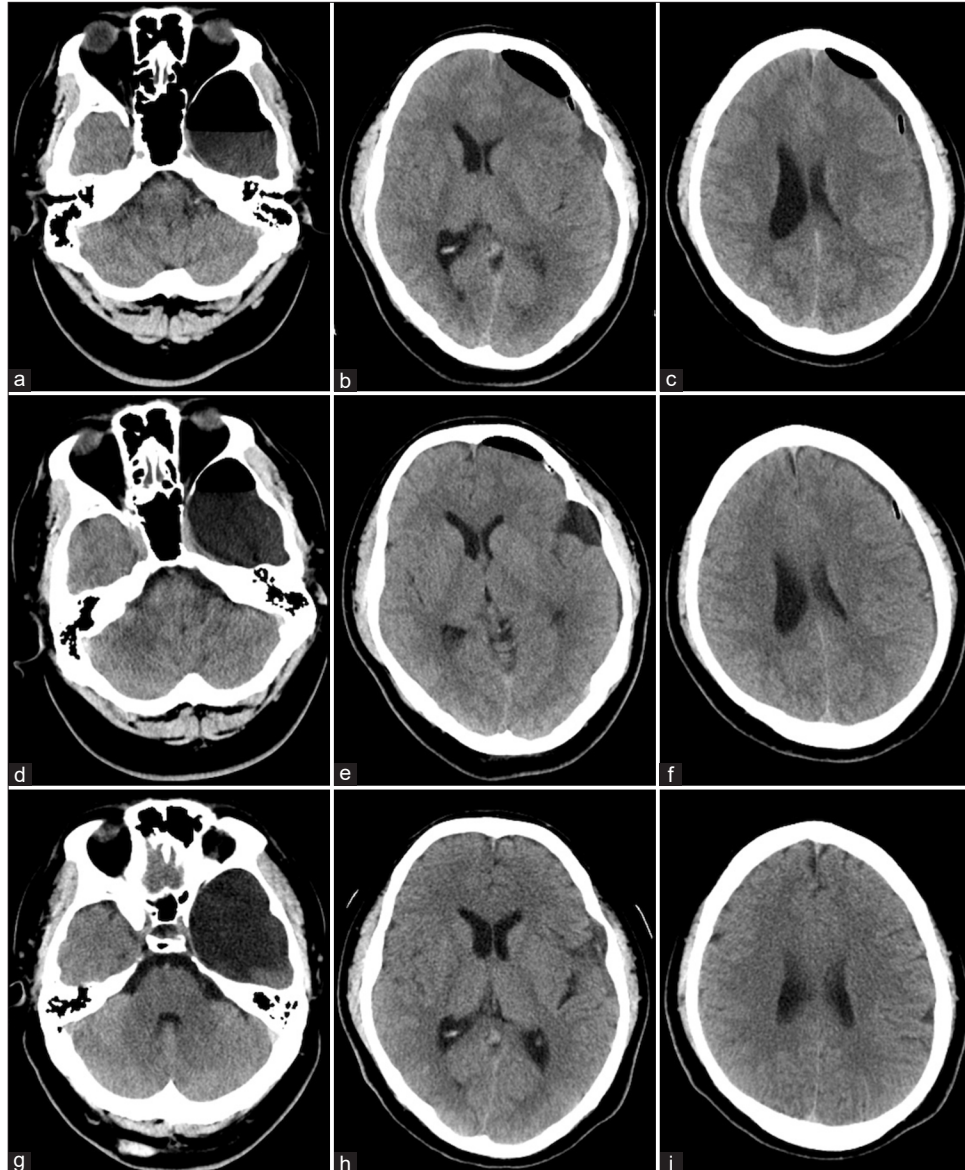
(a–c) Head computed tomography performed 3 days after the head trauma revealed a left middle cranial fossa arachnoid cyst and a small left subdural hygroma. (d–f) Head computed tomography performed 16 days after the head trauma revealed an increase in the left subdural hygroma. (g–i) Head computed tomography performed 43 days after the head trauma revealed that the left subdural hygroma had increased further.
